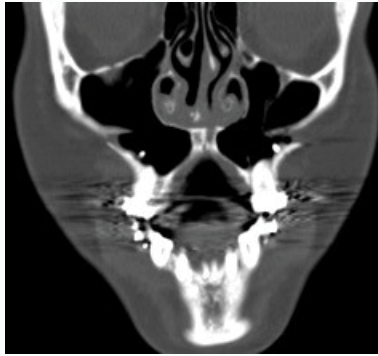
Post-operative CT coronal cut coincident with the 1st molars displaying unusually thin and steeply angled palatal bone.
